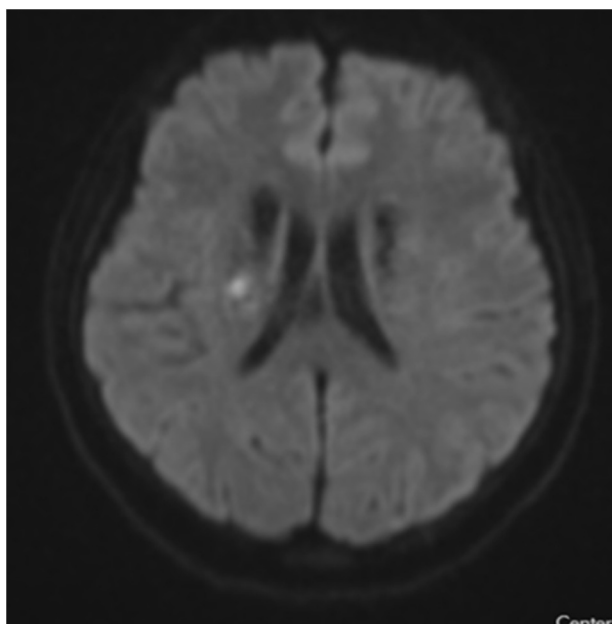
DWI showing high signal intensity in right corona radiata- diffusion restriction (lacunar infarct).
